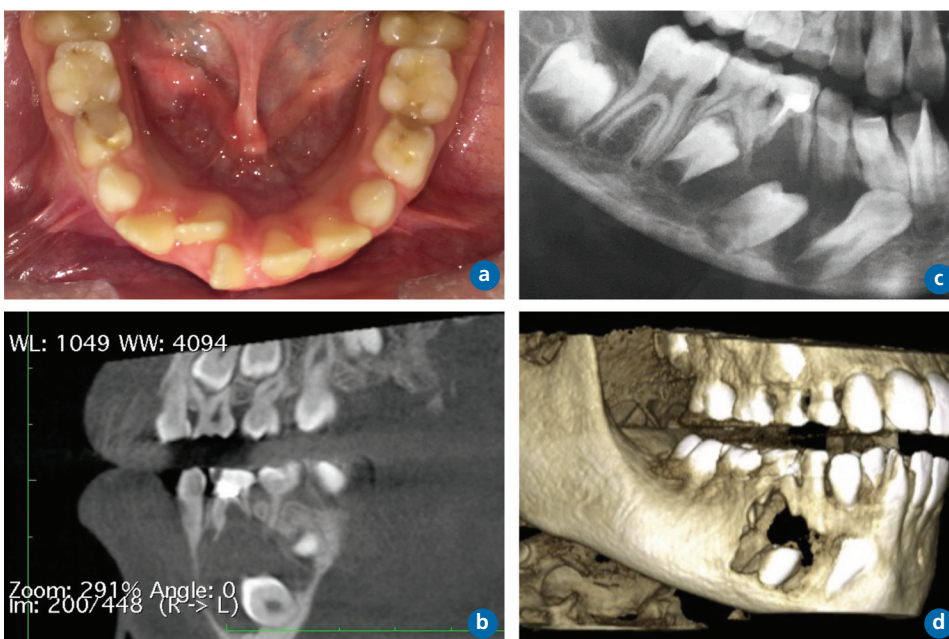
preoperative evaluation of the patient. A) Clinical photograph showing swelling of the mandibular buccal cortical bone in correspondence with the lower right primary molars; B) Panoramic radiograph showing a large osteolytic area involving the first primary molar and causing displacement of the germs of the premolars; C) CBCT scan of the lesion; D) 3D volume rendering showing a large fenestration of the mandibular buccal cortical bone.
